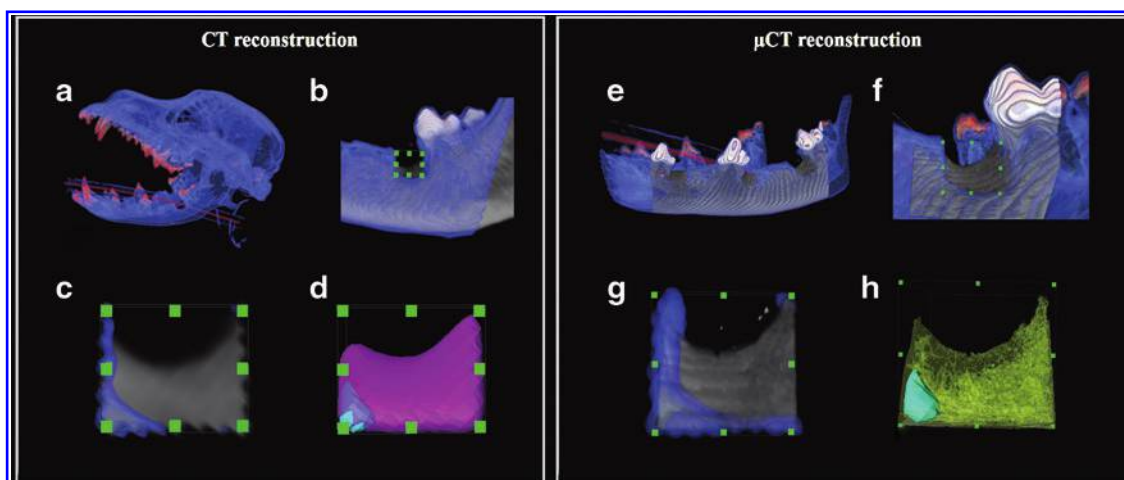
Three-dimensional CT and μ CT reconstructions. (a) Three-dimensional rendering of baseline (bluescale) and (b) 8 weeks (grayscale) CT image sets. (c, d) ROI defined by a box-shaped contour involving full defect volume (standardized through different time point superimpositions). (e) Three-dimensional reconstruction of baseline (blue) and 8 week (pink) superimposition. (f, g) Superimposition of baseline CT (bluescale) and μ CT (grayscale) reconstructions. (h, i) ROI defined by a box-shaped contour involving full defect volume (standardized through different time point superimpositions). (j) Three-dimensional reconstruction of baseline (blue) and 8 week (yellow) superimposition. ROI, region of interest. Color images are available online.
